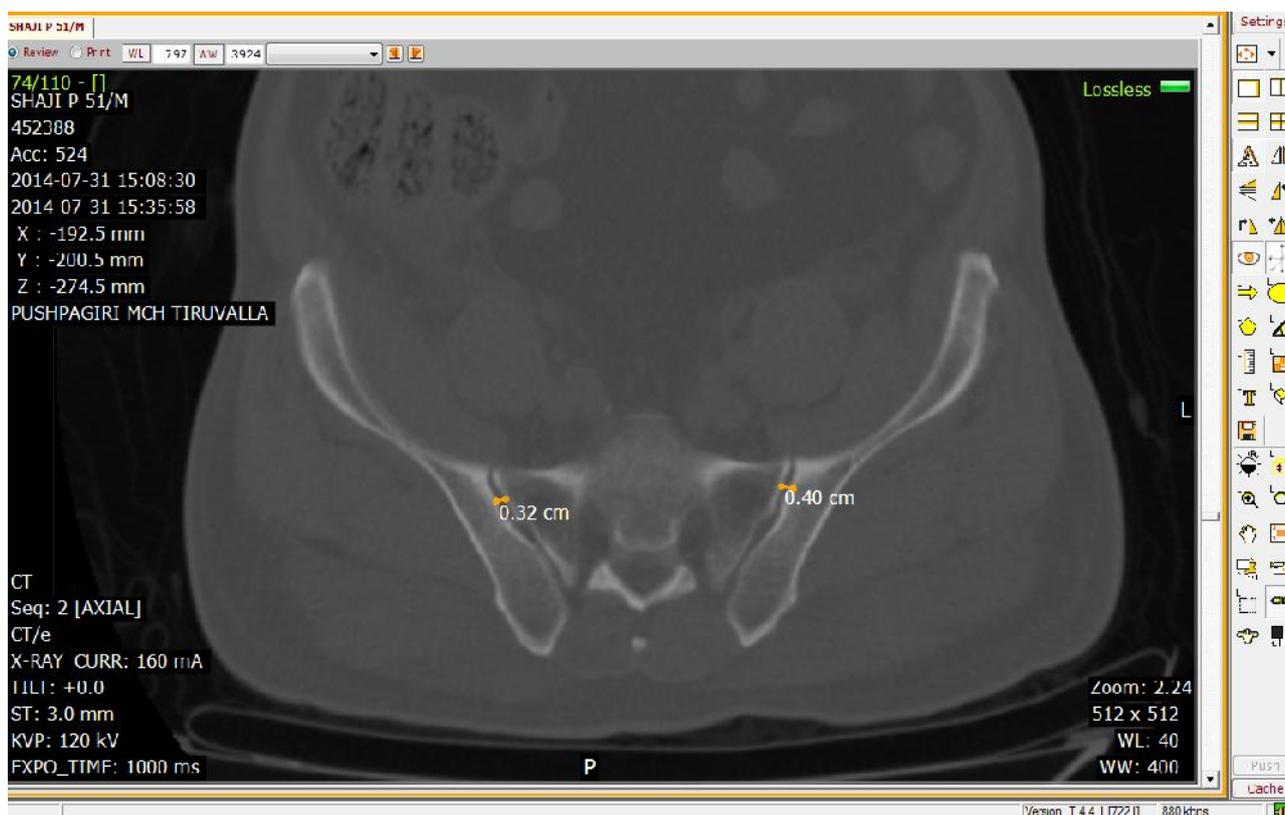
SIJ space width at Level 1 being measured using bone window settings in the image viewer at CT workstation
